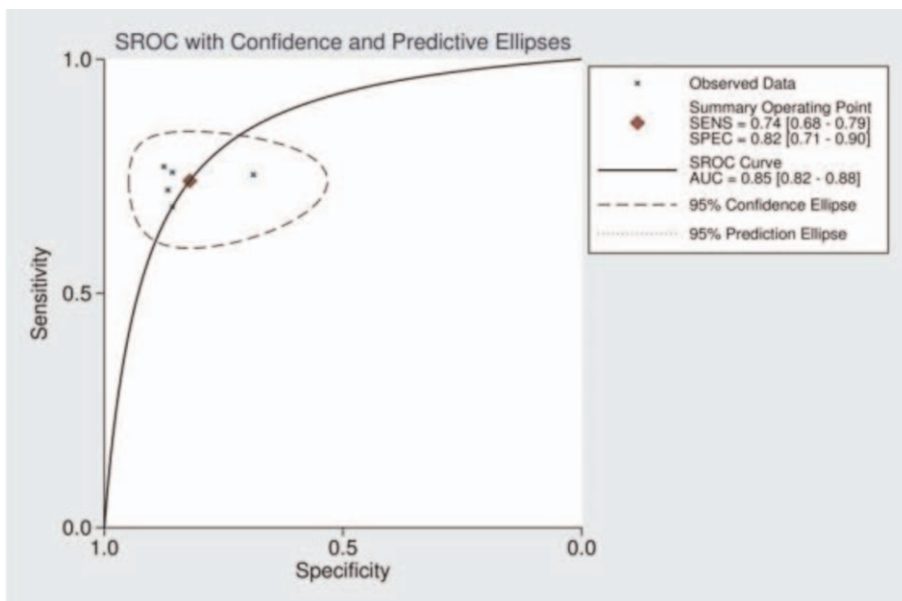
ROC for PET/CT diagnosis of invasive adenocarcinoma presenting as GGN. The was 0.85. AUC = area under the curve, GGN = ground glass nodule, PET/CT = Positron emission tomography computed tomography; ROC = receiver-operating characteristic.
